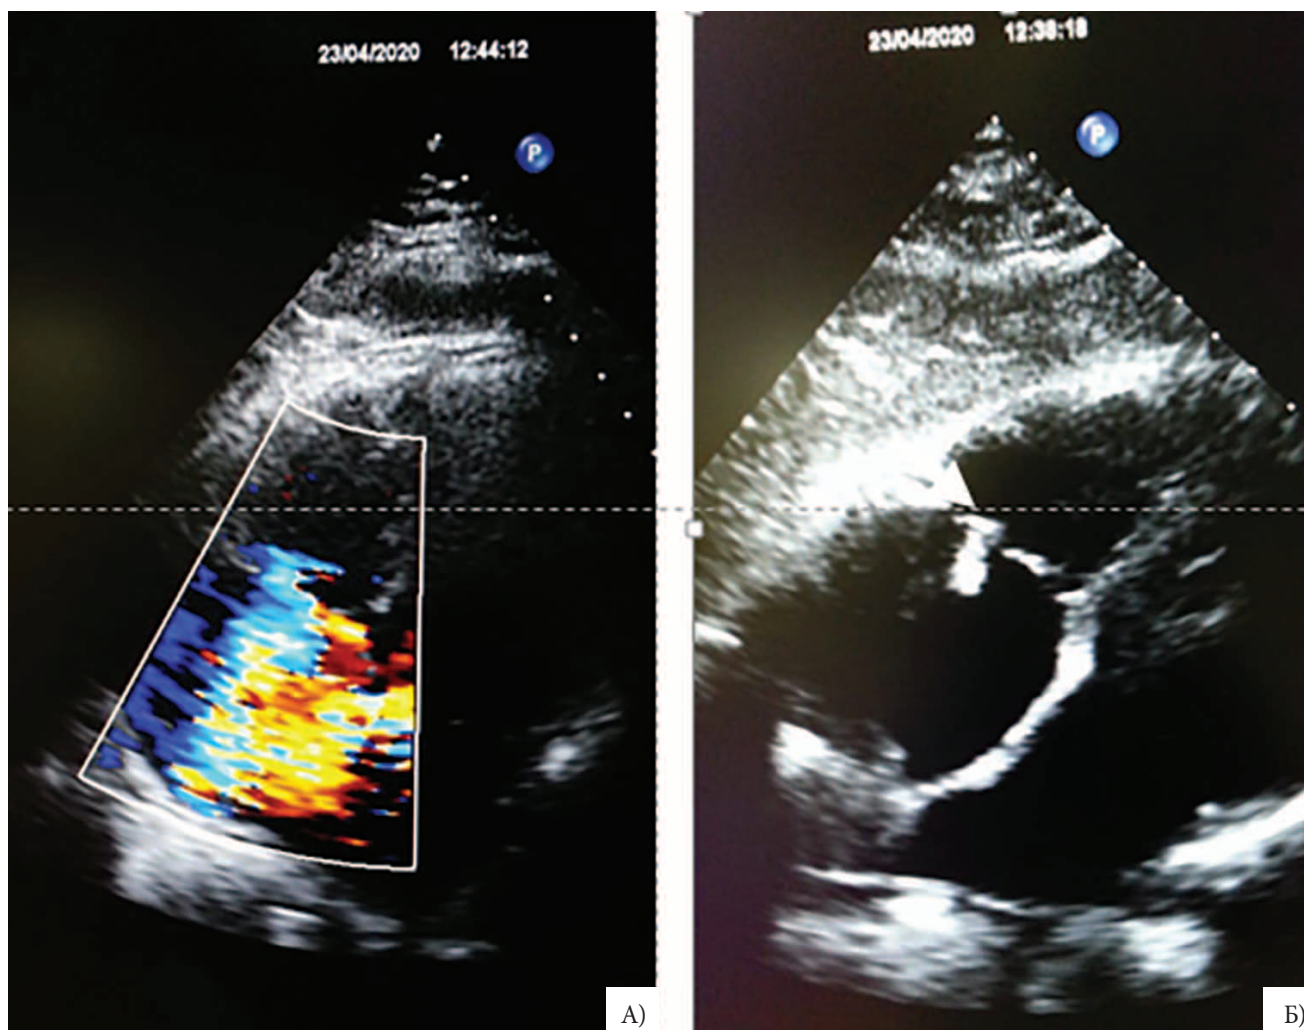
Echocardiographic images of patient C.
